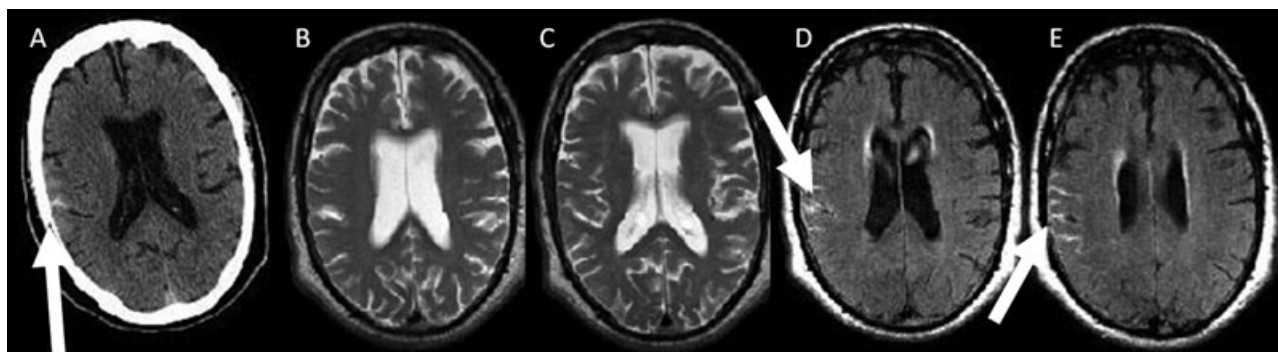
Axial CT (A), T2-weighted (B, C), and FLAIR (D, E) MR images of a child with posttraumatic subarachnoid hemorrhage. The hyperintense blood within the brain sulci is best seen on the FLAIR images (D, E).
